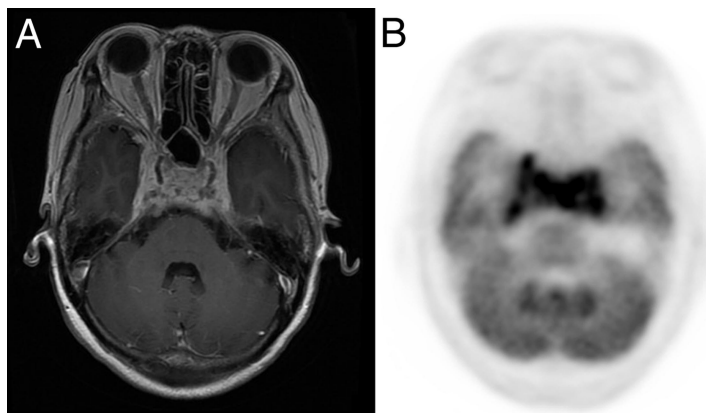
A 59-year-old woman presented with periorbital pain and dizziness for more than 10 days. Despite symptomatic treatment with acetaminophen and prochlorperazine, symptoms persisted and aggravated in the following week. Additionally, she presented with ptosis, disordered eye movements, and blurred vision (right third and bilateral sixth cranial nerve palsy). However, computed tomography of the brain did not reveal any lesions. Laboratory testing including complete blood count, serum chemistry profile, serum tumor markers, serum rheumatologic testing, and cerebrospinal fluid analysis was unremarkable except for an elevated erythrocyte sedimentation rate of 41 mm/h (normal range, 0–20 mm/h). Subsequently, magnetic resonance imaging (A) showed bilateral cavernous sinus/sella enhancement with extension to right orbital fissure on contrasted T1-weighted images.¹ F-18 fluorodeoxyglucose positron emission tomography and computed tomography (FDG PET/CT; B) demonstrated a hypermetabolic lesion in the corresponding area. Thus, the condition was considered to be an inflammatory process and not to be primary/metastatic brain tumor, carotid-cavernous fistula, sinus thrombosis, multiple sclerosis, or central nervous system infection. Thus, the presumptive diagnosis was Tolosa-Hunt syndrome. For that, she was treated with intravenous hydrocortisone (300 mg/d for 5 days) followed by a tapering oral dose with prednisolone 20 mg/d. One week later, she was well and discharged. Four weeks after discharge, she had similar symptoms again. Also, treatment with intravenous administration of high-dose steroid resolved all symptoms. She remained stable for more than 5 months after recurrence. Tolosa-Hunter syndrome is a rare disorder caused by granulomatous inflammatory processes with a typical relapsing-remitting course, characterized by painful ophthalmoplegia, oculomotor paresis, and a dramatic response to corticosteroids.^{2–4} The use of corticosteroids has been suggested as a diagnostic test as well as a therapeutic procedure.^{5,6} Additionally, there have been a number of other therapies used in treating this condition including methotrexate, mycophenolate mofetil, infliximab, and radiotherapy.^{7–10} Currently, magnetic resonance imaging plays a key role in diagnosis of Tolosa-Hunter syndrome for locating the inflammatory tissue and follow-up.^{11,12} It is well recognized that FDG PET/CT is helpful to detect inflammatory tissue.^{13–16} This case of Tolosa-Hunter syndrome with unique representative FDG PET/CT images may imply that FDG PET/CT is a useful tool in detecting and monitoring of this disease.
